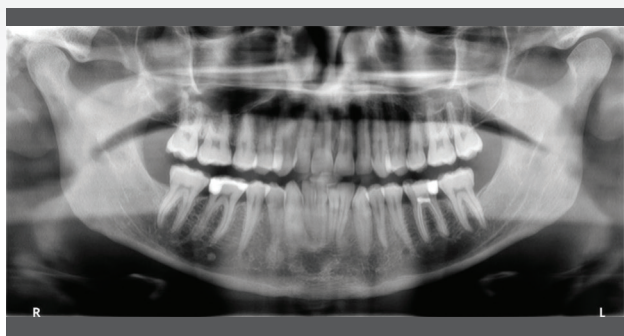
Clear, good quality panoramic radiograph.
